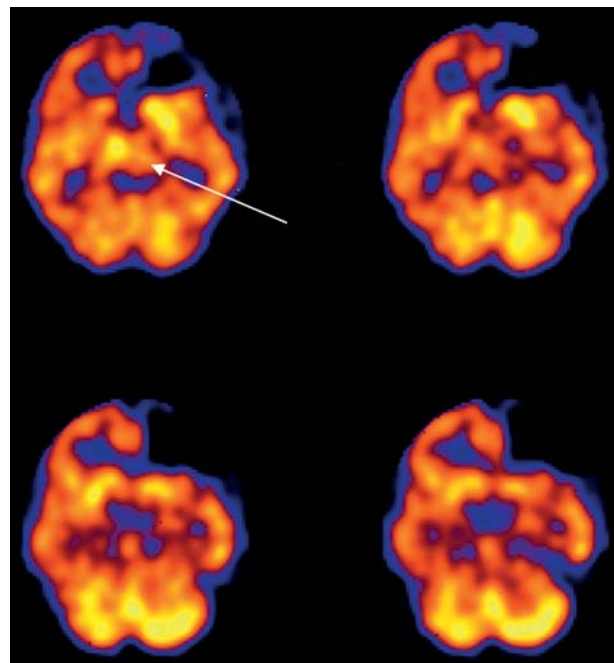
Transaxial SPECT images of $^{99\text{m}}\text{Tc}$ bicisate in a patient with recent left frontal lobe stroke. The scan shows near-absent activity in the left frontal region. There is also decreased perfusion in the ipsilateral thalamus (arrow), which may be associated with deafferentation from the affected regions in the left frontal lobe.
